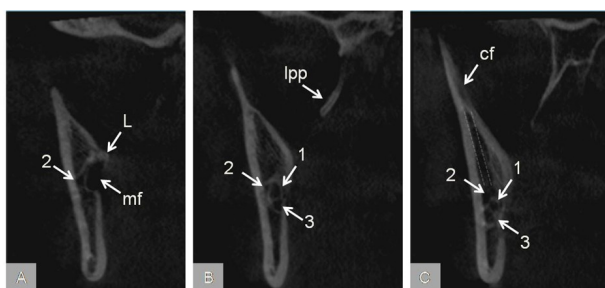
Coronal Section of CBCT scan: A) showing L lingual; mf mandibular foramen; 2 accessory mandibular canal. B) showing lpp lateral pterygoid plate; 1 mandibular canal; 2 & 3 accessory mandibular canals. C) showing cf coronoid foramen; 1 mandibular canal; 2 & 3 accessory mandibular canals; dotted lines the confluence of the coronoid foramen with the accessory mandibular canal.
